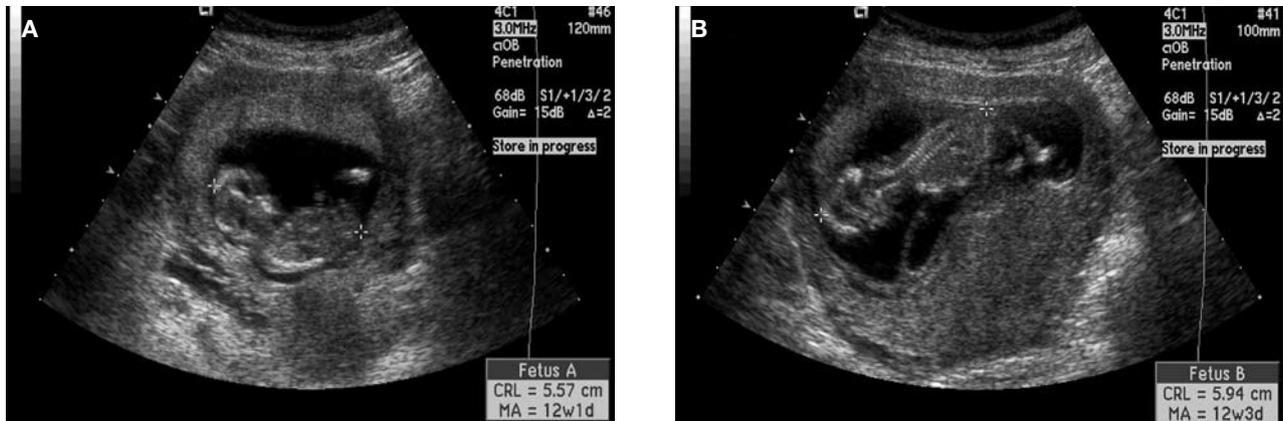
Initial ultrasound at 12 weeks of gestation shows normal viable intrauterine twin pregnancy. (A) Twin A. (B) Twin B.
